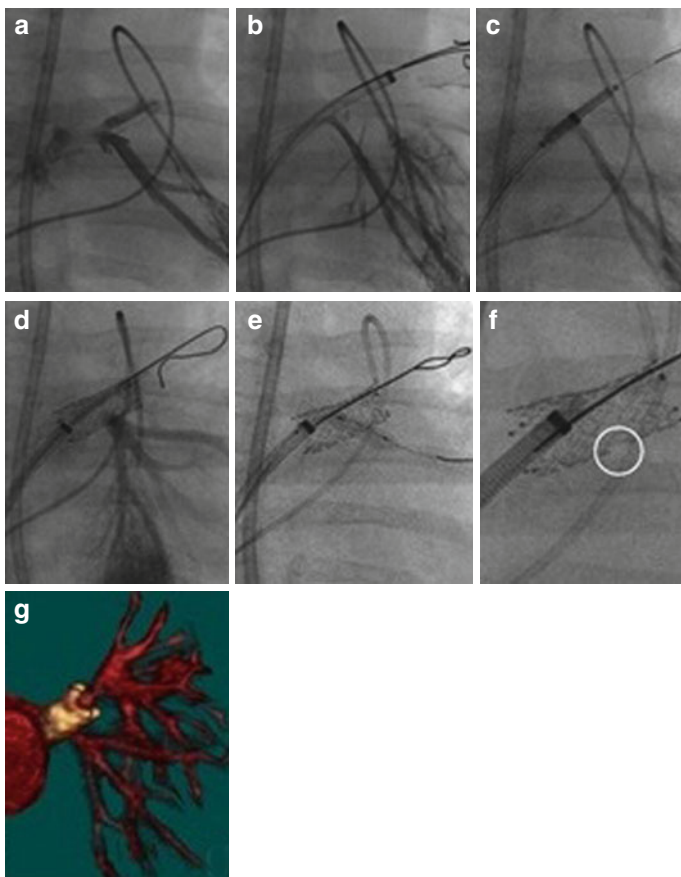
Premounted Visi-Pro stent implantation into a native common left pulmonary vein stenosis after two previous cutting balloon dilations in a 15-month-old boy. Tight stenosis in (a) shown by pulmonary artery wedge injection. Long sheath advanced over two guide wires into upper lobe branch and stent uncovered guided by pulmonary artery wedge injection (b, c). After stent implantation the inferior pulmonary vein is jailed (d) and the origin easily dilated with a coronary balloon (e) due to the open-cell design with opening of the ostium (circle in f). CT angiogram 18 months later confirms patency of upper and lower veins into the stent (g)
